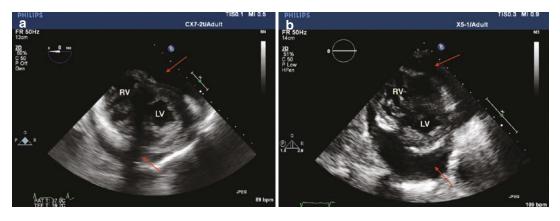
The *red arrows* point to a circumferential pericardial effusion seen in transgastric short-axis (a) and parasternal short-axis views (b). *RV* right ventricle, *LV* left ventricle
